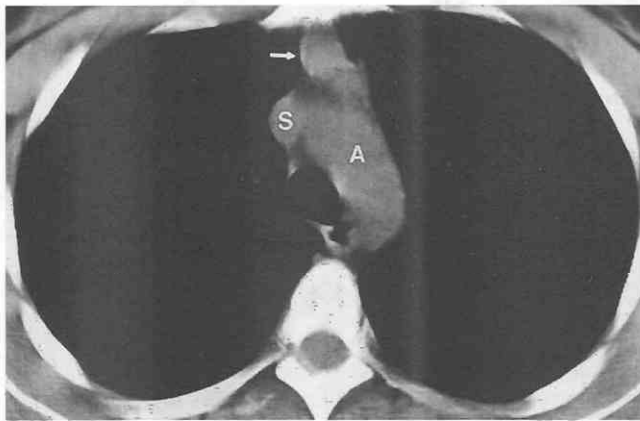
Thymoma in woman with myasthenia gravis. Chest radiograph (not shown) was normal. Because of association between myasthenia gravis and thymoma, chest CT was performed and revealed small soft tissue mass in anterior mediastinum (arrow). Resection confirmed thymoma. A, aorta; S, superior vena cava.
